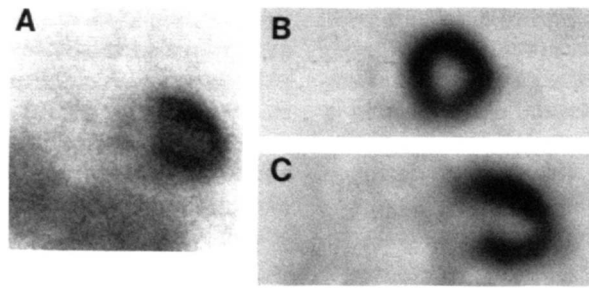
Thallium-201 scan performed in a 45-yr-old male following intravenous dipyridamole infusion (0.142 mg/kg/min for 4 min) supplemented by isometric handgrip exercise (33% maximal force for 4 min). An anterior planar image (A) was obtained 5 min following ^{201}Tl injection, immediately thereafter SPECT acquisition was performed. Midventricular short-axis (B) and vertical long-axis slices (C) are shown. Whereas moderate liver uptake characteristic of dipyridamole/handgrip studies is noted in the planar image, there is minimal, if any, image degradation in the tomographic slices. Image quality is comparable to that with treadmill exercise (Fig. 2).
